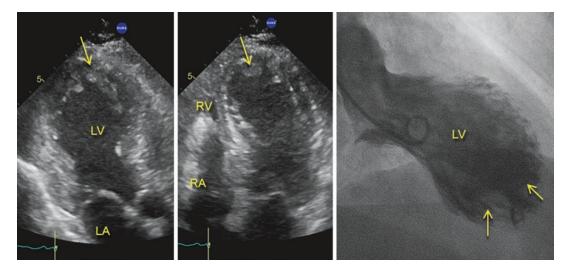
Apical three- (left panel) and four-chamber (middle panel) views of another patient following an anterior wall myocardial infarction. Multiple thrombi are seen
